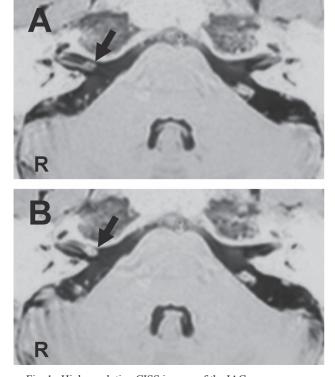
High-resolution CISS images of the IAC. (A, B) Ultrathin T2-weighted magnetic resonance images using the constructive interference in steady state (CISS) sequence show a small mass in the right internal auditory canal (IAC) (arrows). R, right.
